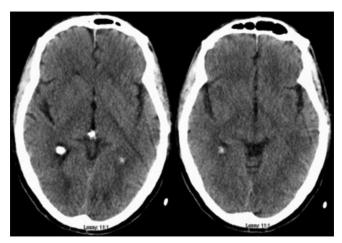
Normal non-contrast head CT during initial work up upon arrival to the emergency room
